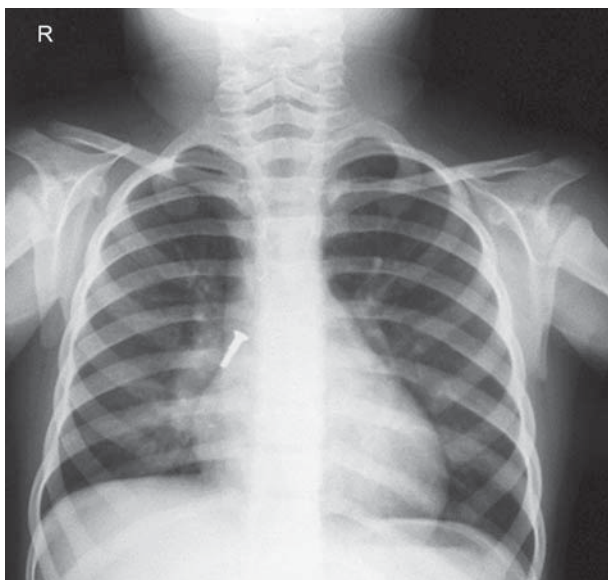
Chest X-ray showing inhaled foreign body (a bolt) in the right bronchus.
